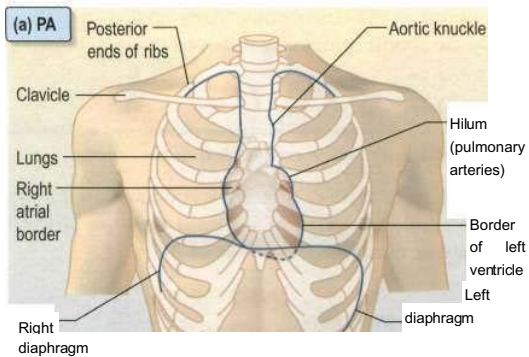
Chest X-rays, (a) PA. (b) Lateral.
